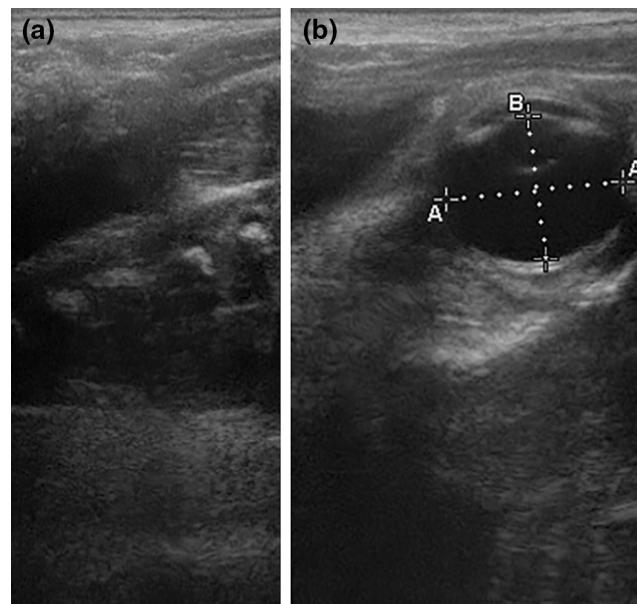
Fetal presentation: (a) transrectal ultrasound image showing the fetal tail consistent with posterior presentation at 242 days of gestation; (b) transrectal ultrasound image showing a fetal eye consistent with anterior presentation at 229 days of gestation. Eye length (eyL) between A and eye depth (eyD) between B were measured to calculate eye approximated volume ($eyV = eyL \times eyL \times eyD$). The head of the mare is to the right and tail of the mare to the left of both images.
